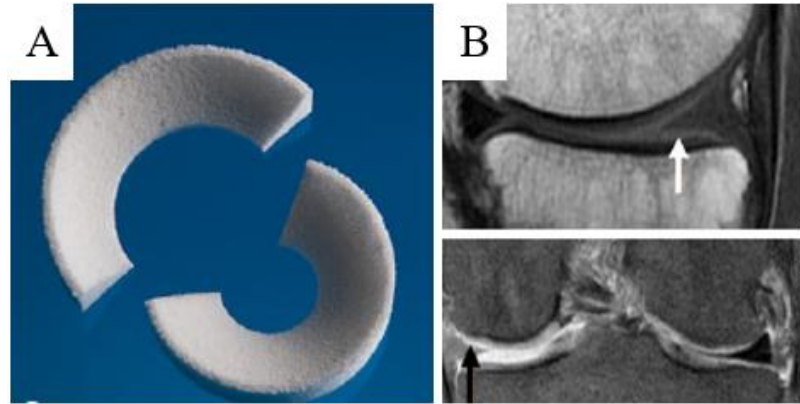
The medial and lateral Actifit Implant (A) and an MRI image after implantation (B) showing an oedema-like signal (black arrow) compared to the natural meniscus (white arrow). [25]
